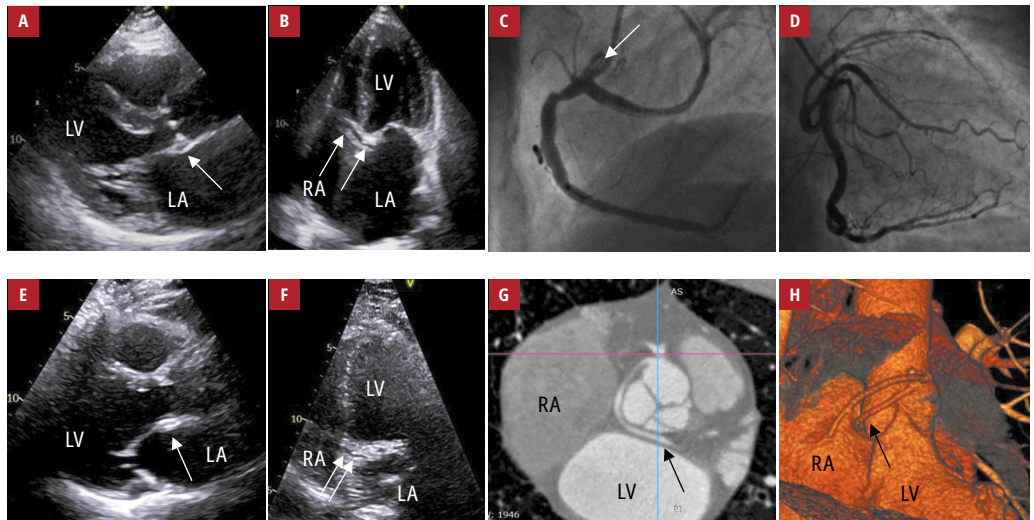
A–D – mother; transthoracic echocardiography showing a bleb sign (A; arrow) and a crossed aorta sign (B; arrows); C – coronary arteriogram showing the origin of the left main coronary artery (LMCA) from the proximal right coronary artery (RCA); arrow indicates the ostium of the single coronary artery; D – selective RCA injection leading to a filling of the entire coronary circulation; E–H – daughter; transthoracic echocardiography showing a bleb sign (E; arrow) and a crossed aorta sign (F; arrows), G, H – coronary computed tomography angiography showing the origin of the LMCA 1 cm posterior from the RCA ostium; on both panels the arrow indicates retroaortic course of the left coronary artery
